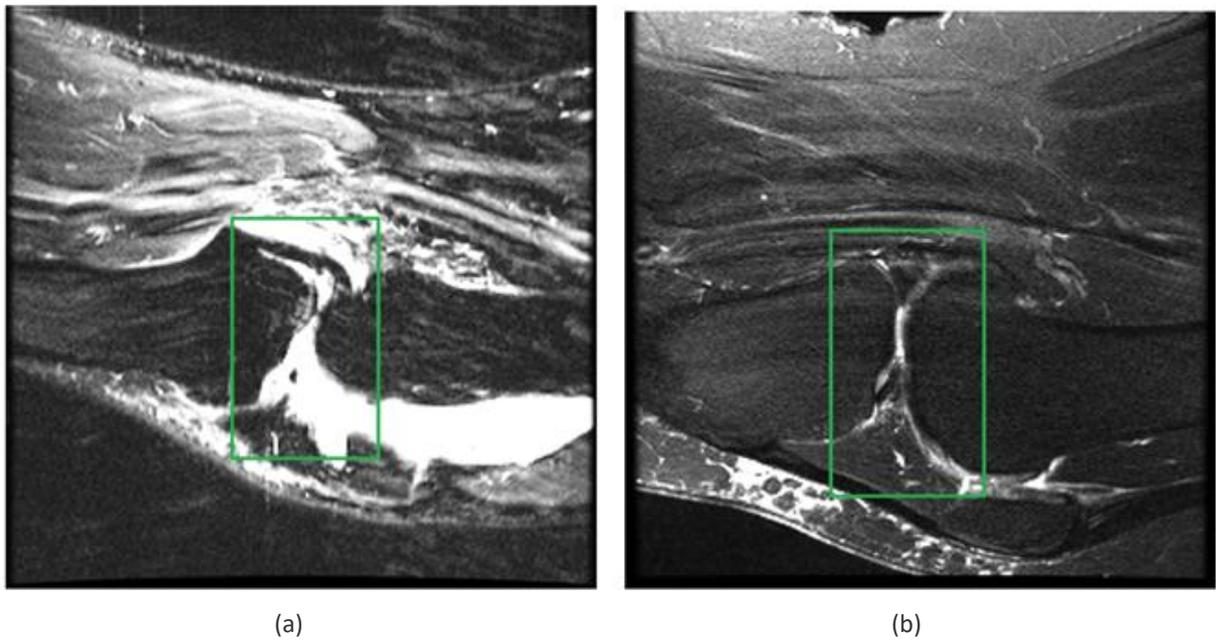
Representative ACL MRI images: (a) MRNet 1.5 T, and (b) MRNet 3 T.
